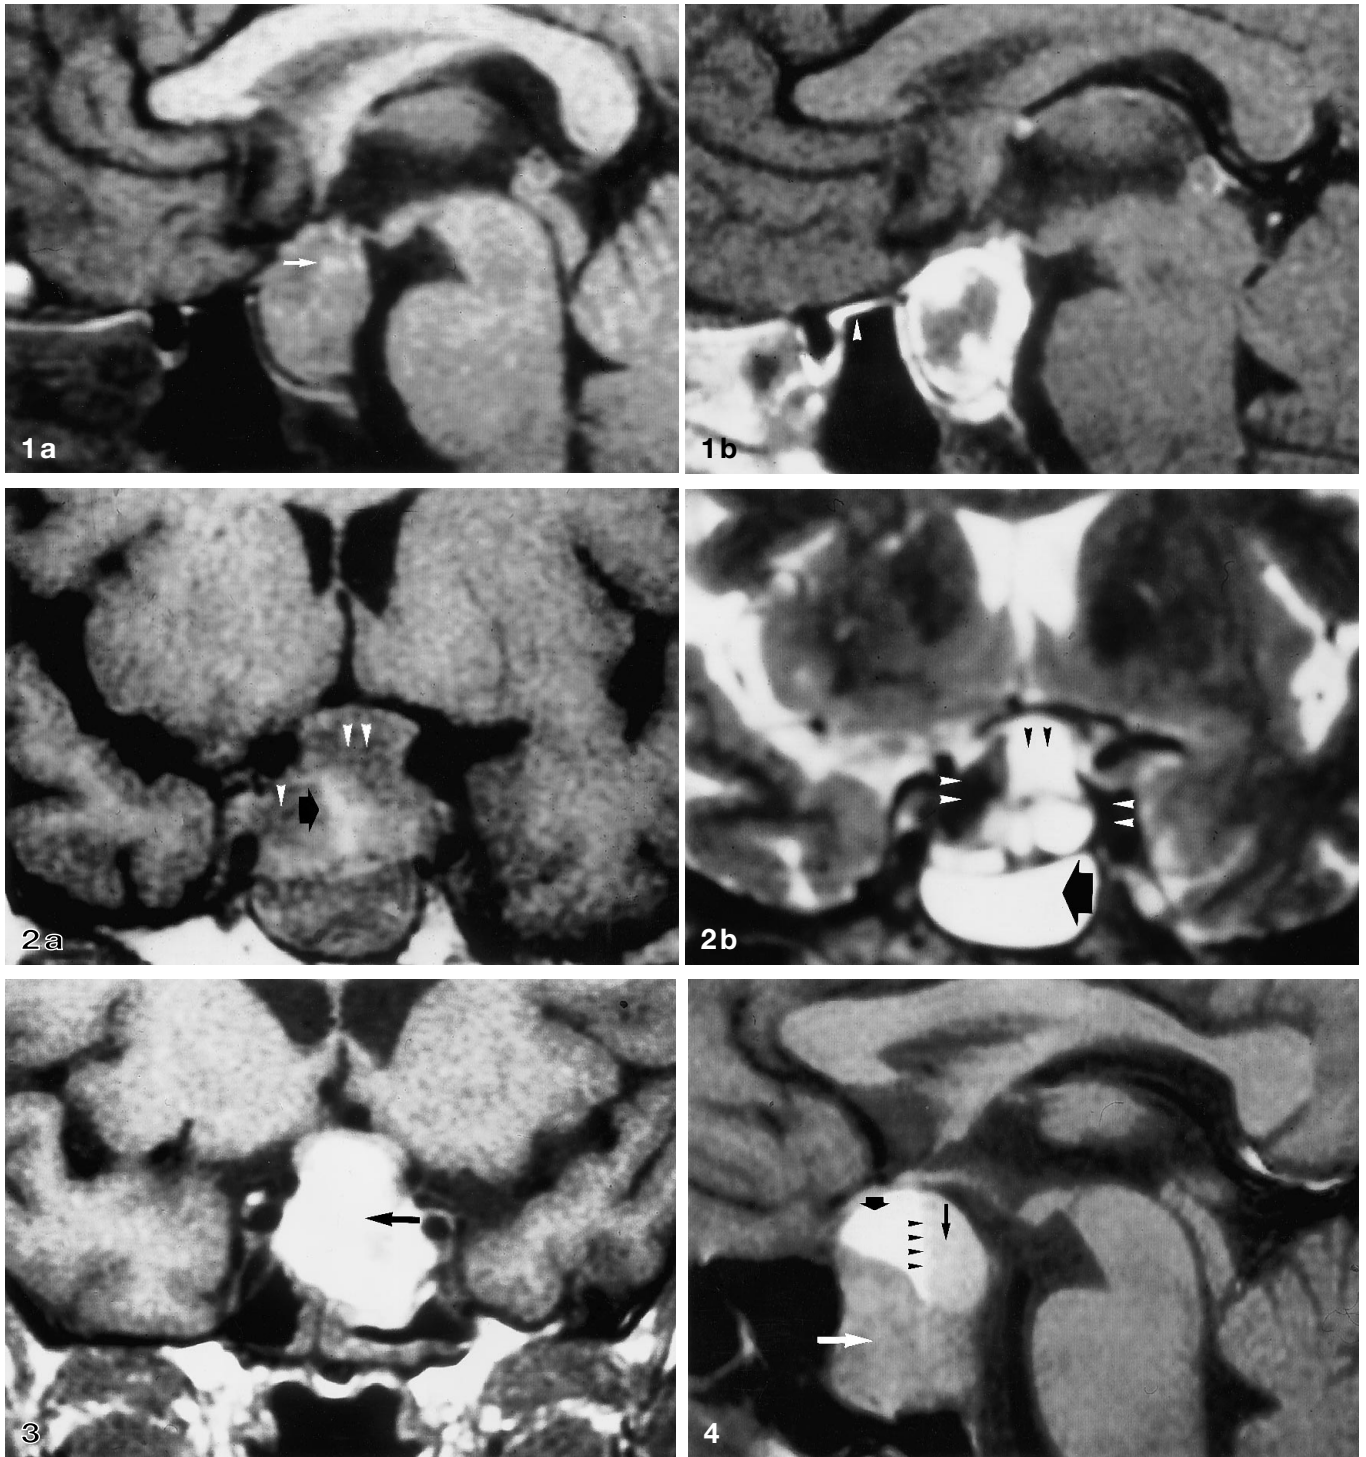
a Case 4. Sagittal T1-weighted spin-echo (SE) image 13 days after onset of pituitary apoplexy (PA). There is a small spot of hyperintense signal which suggests the presence of blood (arrow). Pathology reported hemorrhagic infarction within a prolactinoma. b Case 4. Sagittal post-gadolinium T1-weighted SE image showing rim enhancement, the non-enhancing central part of the macroadenoma most likely corresponding to area of infarction. The dura of the sphenoid planum is enhancing (arrowhead)
